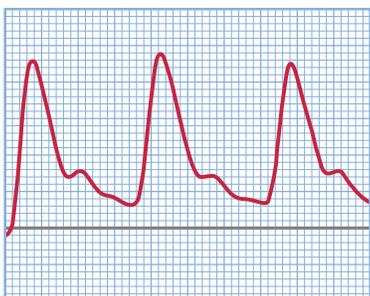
Because exercise produces a demand for blood to the muscles, a normally high-resistance arterial Doppler signal becomes low-resistance. In this analog waveform, the usual reversal below the baseline is seen as a forward reflection instead. This finding is quite normal after exercise.
